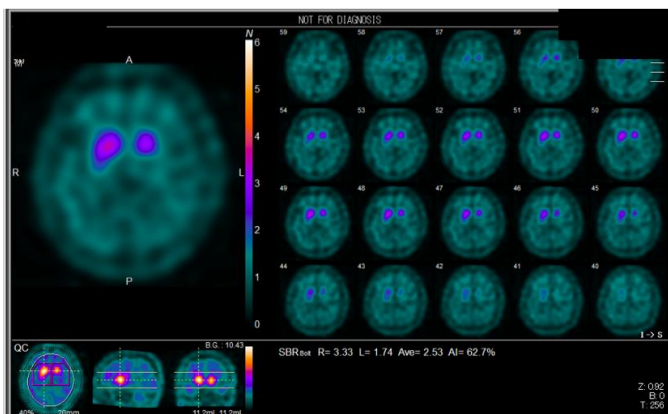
123I-ioflupane scintigraphy in Parkinson's disease. Striatal images were disappeared in this patient, indicating degeneration of the nigrostriatal pathway that was a biomarker for the diagnosis of DLB and Parkinson's disease.
